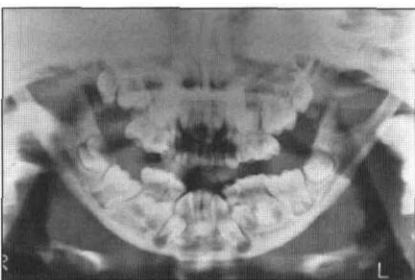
Panoramic radiograph shows obtuse gonial angle, elongated coronoid and articular processes, and severe crowding.
